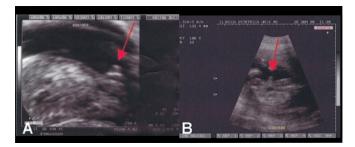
Sonography for the fetal gender assignment. (A) Sagittal section of external genitalia at 13 weeks gestation and 23 mm of BPD. The red arrow points to the bulge/penis—male gender assignment. (B) Coronal section of external genitalia at 22 weeks gestation. The red arrow points to the penis and the scrotum-like structures—male gender assignment.
